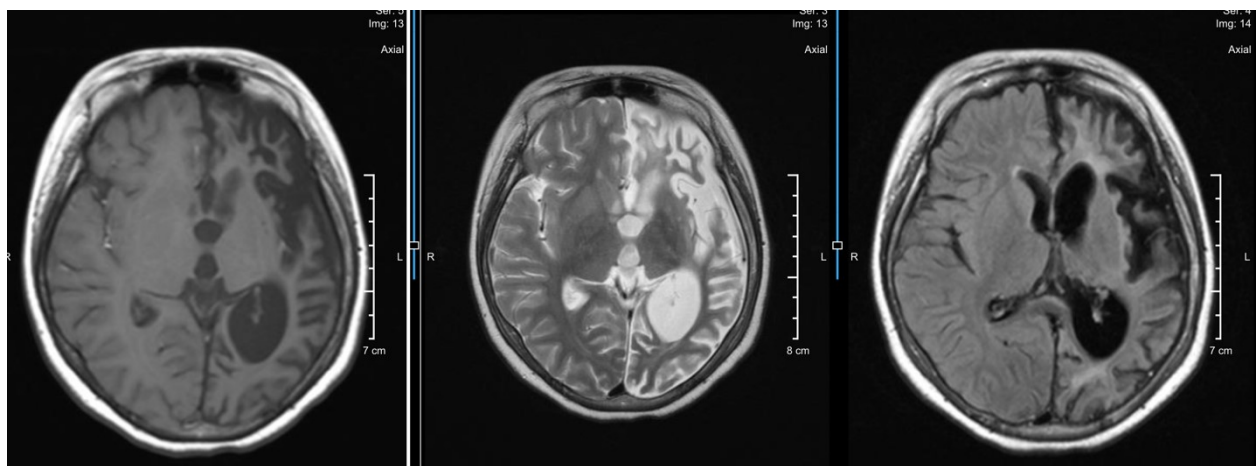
Cranial MRI done on 2022. (A) T1W (2) T2W (3) T2W/FLAIR showing progression of the volume loss over the left frontotemporoparietal region
